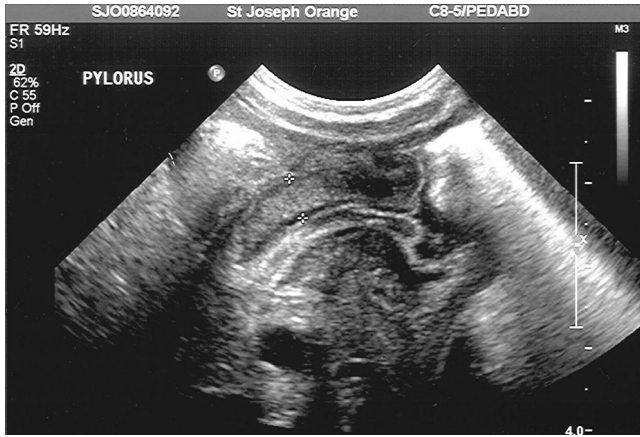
Ultrasound: pyloric muscle thickness.
